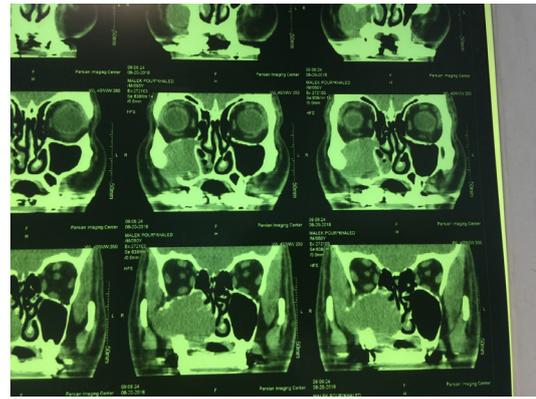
Axial & coronal & sagittal cuts of CT showing the extension of the lesion.
